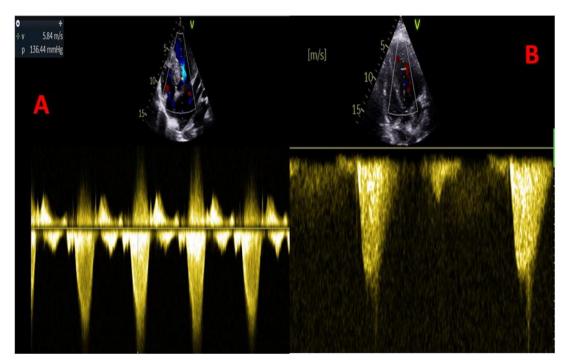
Echocardiographic images showing a midventricular gradient. A) CASE 1 with a large gradient at 136mmHg, B) CASE 2 with a gradient at 35mmHg
